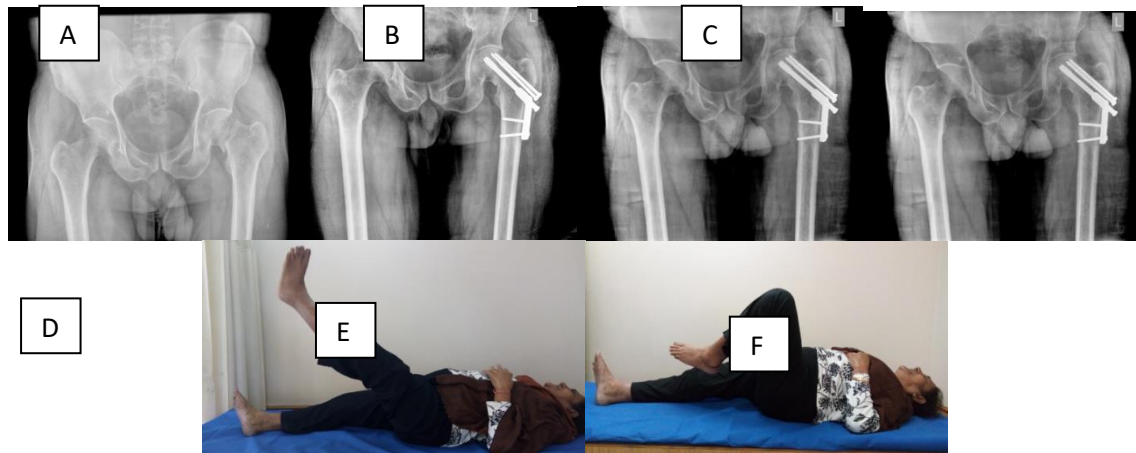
(A) 64 Years Old Female with Garden Type 2 Femoral Neck Fracture (B) She Was Operated With Open Reduction And Dynamic Hip Screw (C, D) Follow-Up Radiographs At 6 Months And 1 Year (E) Active SLR At 1 Year Follow-Up. (F) Range Of Motion at 1 Year.
